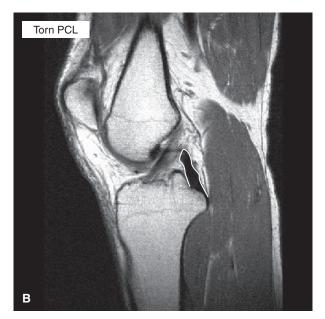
Sagittal MRI demonstrating a rupture of the posterior cruciate ligament seen as an interruption in the cordlike structure (outlined). (From McKinnis¹⁷³ Fig. 13.47 B, p. 396, with permission.)
